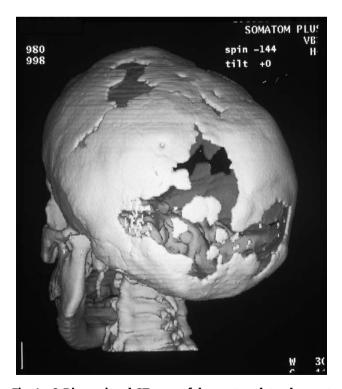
3-Dimensional CT scan of the postero-lateral aspect of the skull showing multiple permanent skull defects 13 years after completion of treatment.
